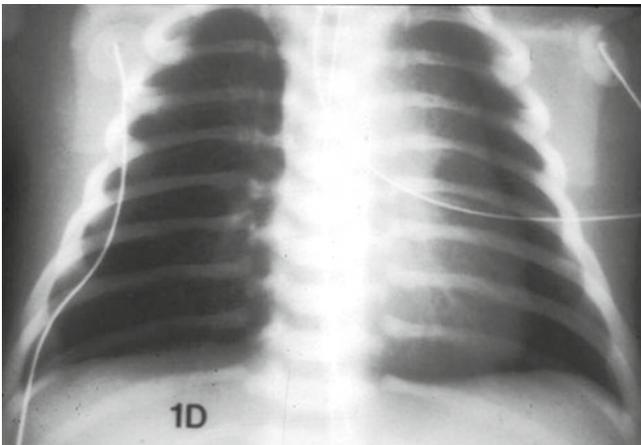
Persistent pulmonary hypertension (PPHN). Radiograph shows hyperlucent lungs and decreased pulmonary vascularity in a 1-day-old neonate
